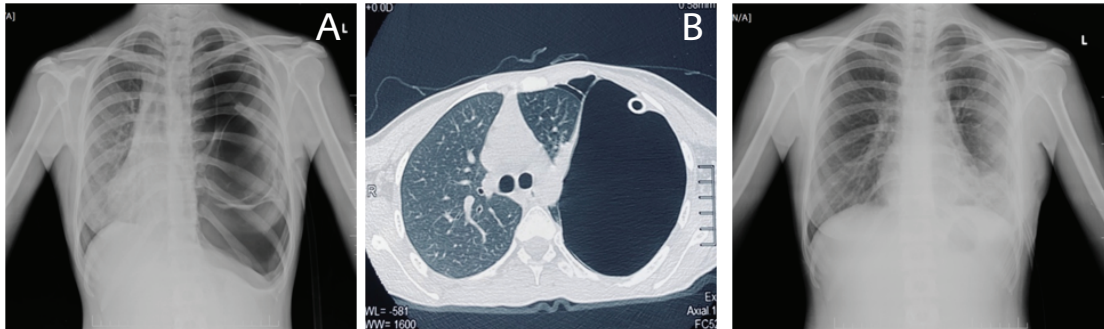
Chest radiograph demonstrating a Type I Giant Bullous Emphysema (Hyper-lucent Zone) in the left upper lobe of lung with mediastinal shift to right side.
